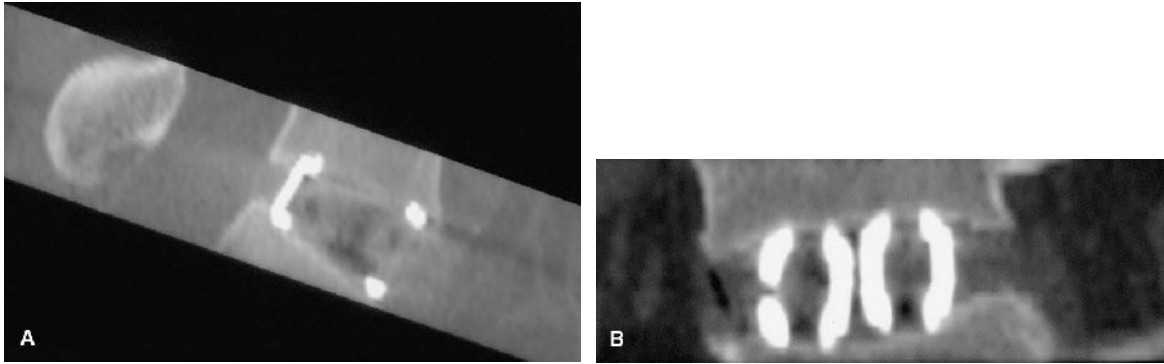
A. An immediate postoperative (48 hours) sagittal plane, thin-cut (1mm) CT scan reconstruction through the central portion of the LT-CAGE shows the rhBMP-2 soaked collagen sponge present in the cage. B. Coronal plain CT scan reconstructions show the cages well placed centrally in the disc space. No autogenous grafts were placed in the interspace.
